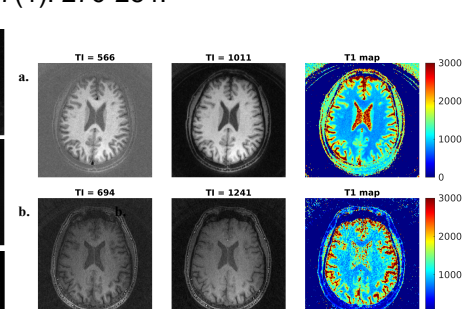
The multi-frame T1-weighted images and estimated T1 map of GOAL-SNAP in 3T (a) and 5T (b).
